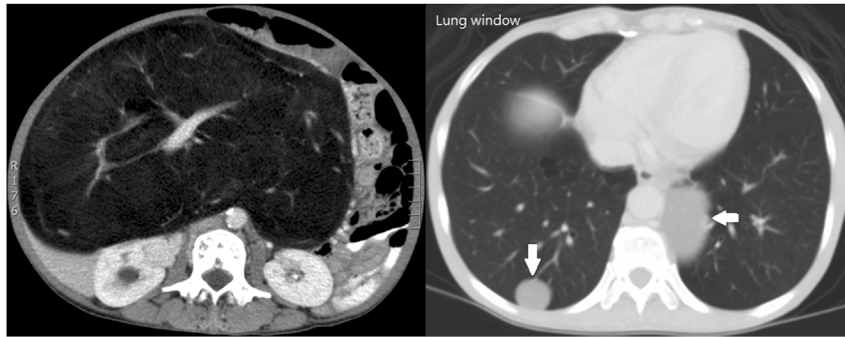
A CT scan showed tumors in the chest and abdominal cavity simultaneously.
